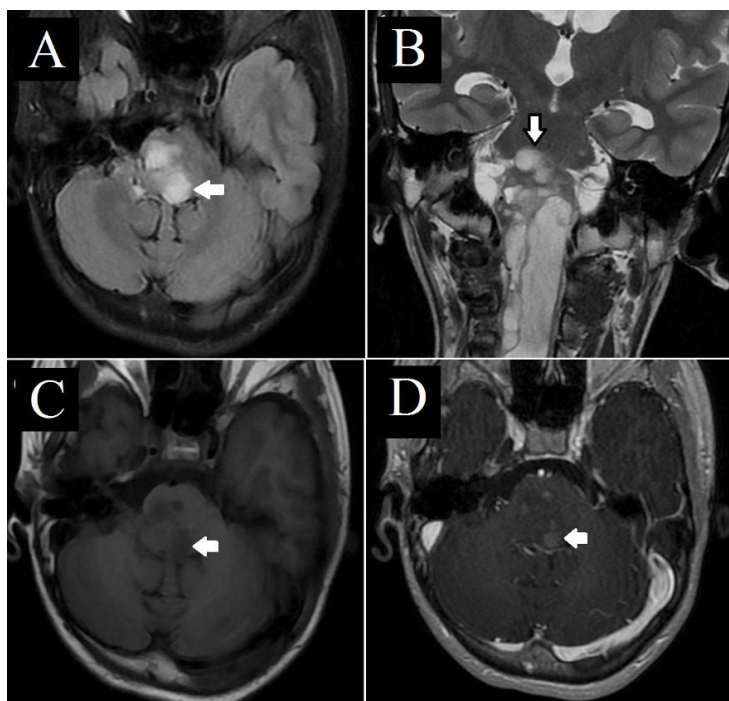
A 14-year-old male patient presented with a mild headache for 4 months. Axial fluid-attenuated inversion recovery (A) and coronal T2-weighted images (B) show a heterogeneous, hyperintense mass (white arrows) in the brainstem that extends to the upper cervical spine, causing cystic collection in the central canal of the spinal cord, known as syringomyelia. Axial T1-weighted (C) and axial T1-weighted contrast-enhanced (D) imaging at the same level manifest faint heterogeneous enhancement (white arrows).
